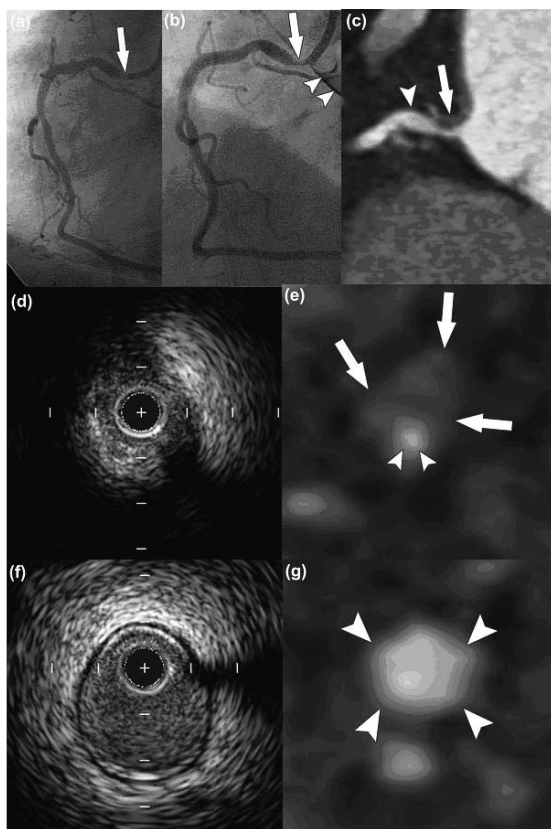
Patient with a true ostial stenosis of the right coronary artery (a) Initial invasive coronary angiogram showing the stenosis (arrow). (b) These findings are confirmed (arrow) when the patient was rescheduled to undergo a percutaneous coronary intervention. The contrast injection this time was non-selective, as is obvious from the appearance of contrast in the right coronary cusp (arrowheads), to minimize the chances of catheter-induced spasm. (c) Corresponding CT coronary angiogram clearly showing the ostial involvement (arrow). (d, e, f, g) Cross-sectional intravascular ultrasound (d and f) and CT (e and g) images, clearly showing the significant narrowing of the lumen (d and e). The extent of disease (e, arrows) in the vessel wall is quite obvious on CT, the residual lumen area (arrowheads) is very small. (f, g) Corresponding cross-sections at the reference site (panel c, arrowhead), distal to the stenosis.
